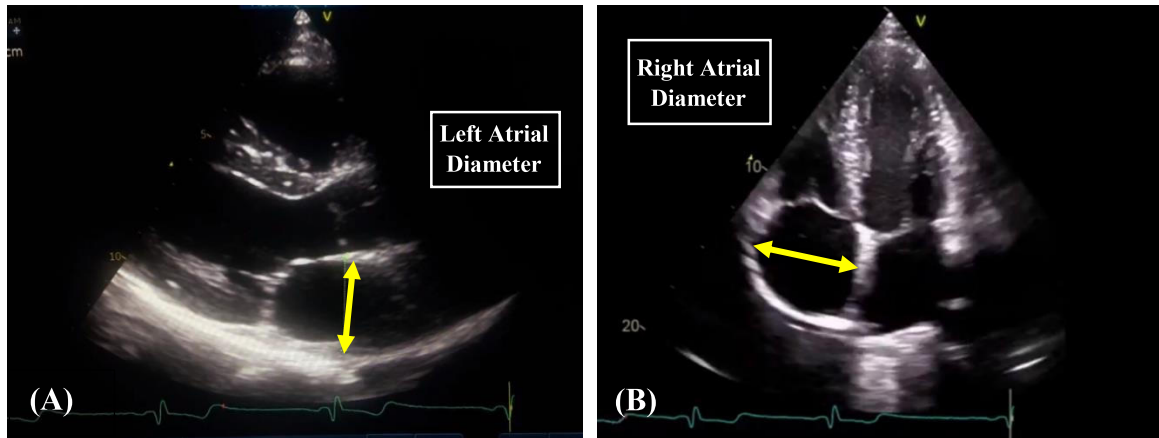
Echocardiographic Parameters. (A) Shows the LA Anterior-posterior diameter (LAD) measurement in PLAX view. (B) Shows the measurement of RA Minor/Short axis diameter (RAD), also called the transverse diameter, in apical 4-chamber view
